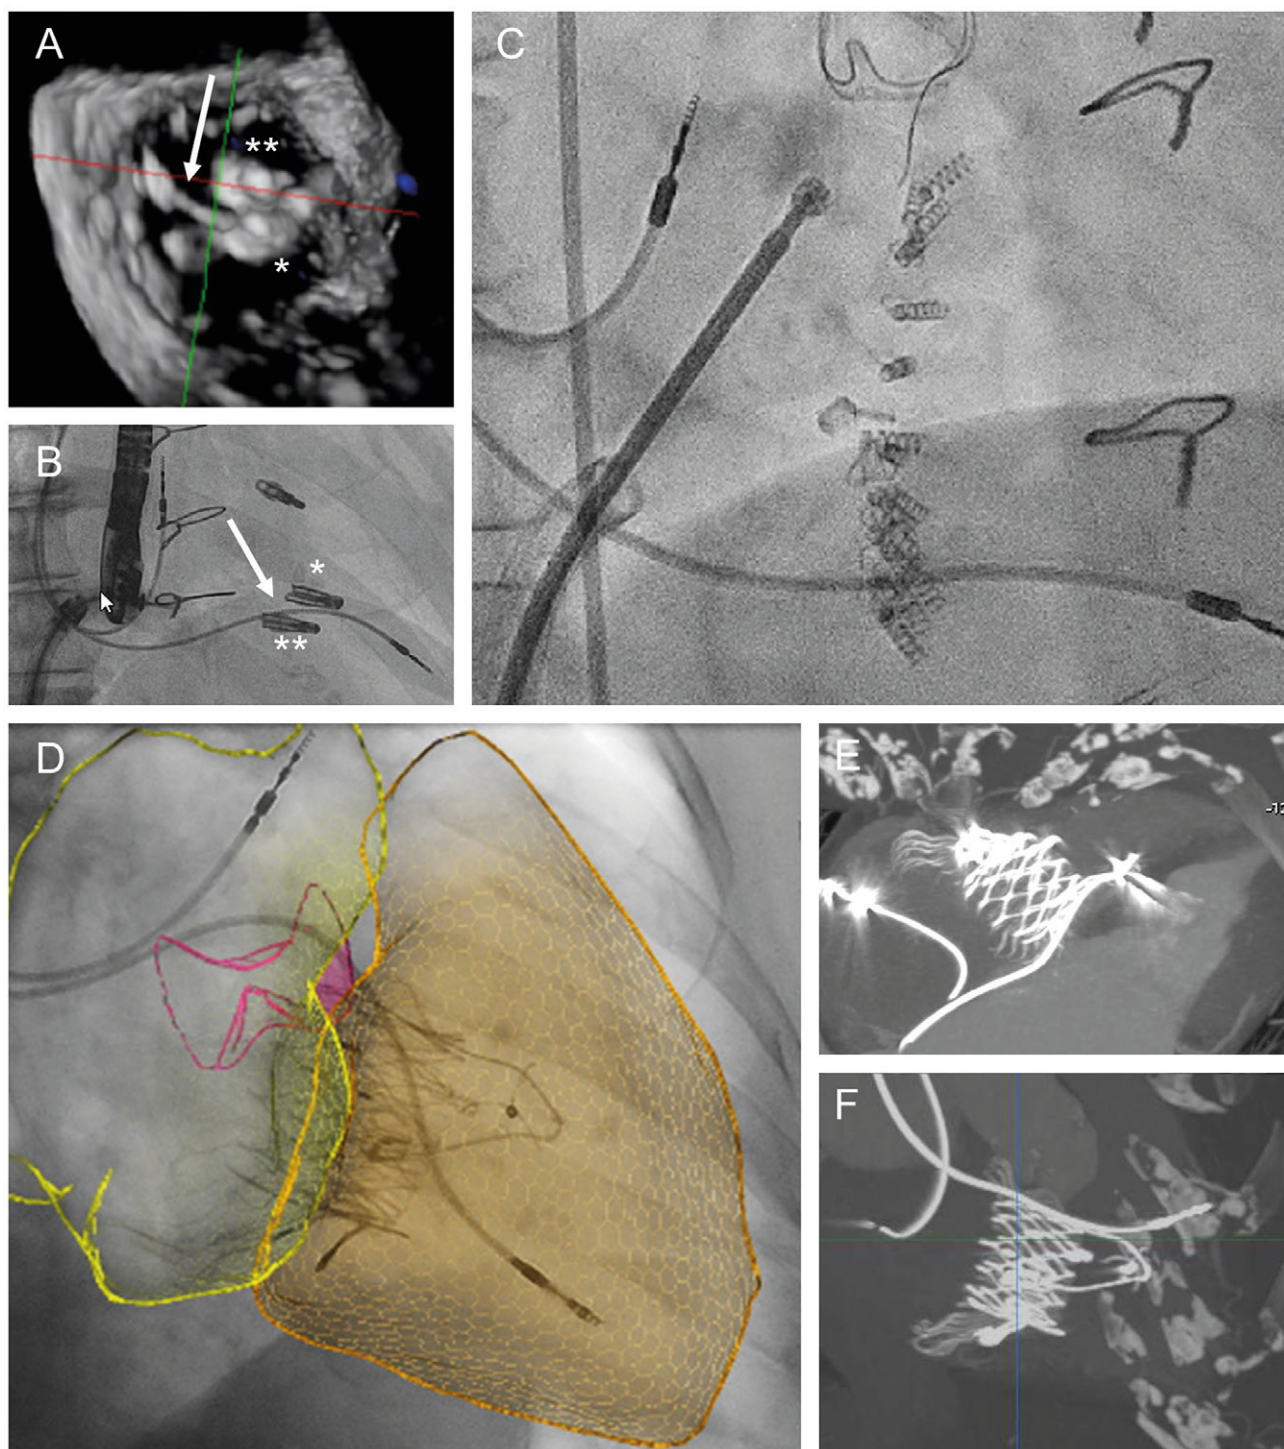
Examples of interactions between tricuspid devices and CIED lead. (A–B) Implantation of 2 TriClips (*antero-septal coaptation line; postero-septal coaptation line) with PM lead in-between (arrow); (C) Jailed PM lead after direct annuloplasty using the Edwards Cardioband system; (D–F) Interaction between the Lux valve and a jailed CIED RV lead as seen using echocardiography-fluoroscopy fusion imaging (D) and computed tomogram (E–F).
